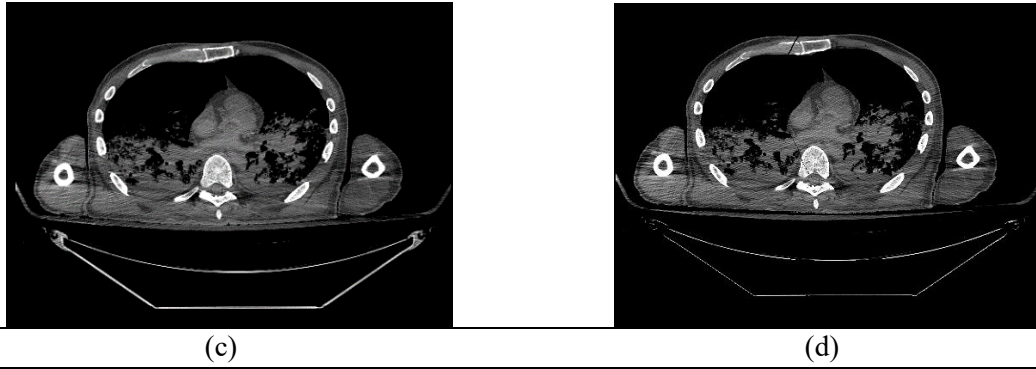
Method 2 to remove the CT scanner bed. (a) Original CT image for CT bed region detection. (b) The CT scanner bed projection. (c) Original CT image. (d) The image following removal of CT scanner bed.
